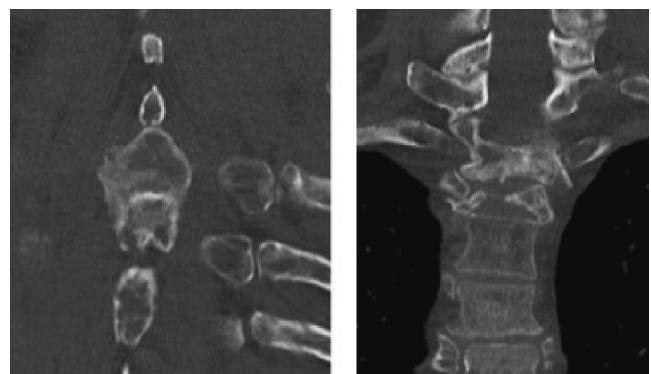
Coronal CT images of thoracic spine demonstrating new bone formation between spinous processes and vertebral bodies.
